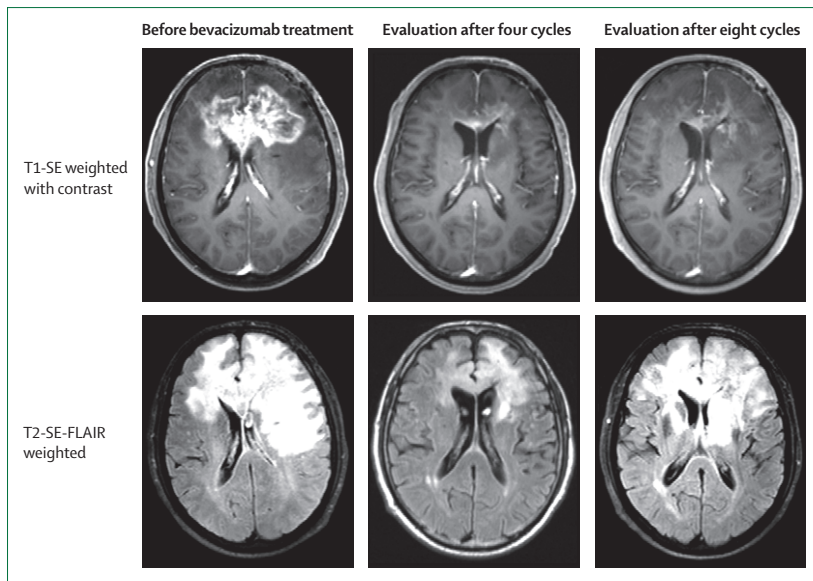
Tumour pseudoresponse to eight cycles of bevacizumab in a 60-year-old patient with a glioblastoma Fluid attenuated inversion recovery (FLAIR) and T1-weighted spin-echo (SE) image show an improvement in the patient after four cycles. However, after eight cycles, there is clear progression on FLAIR despite persistent improvement on gadolinium-enhanced T1-weighted image (pseudoresponse).
